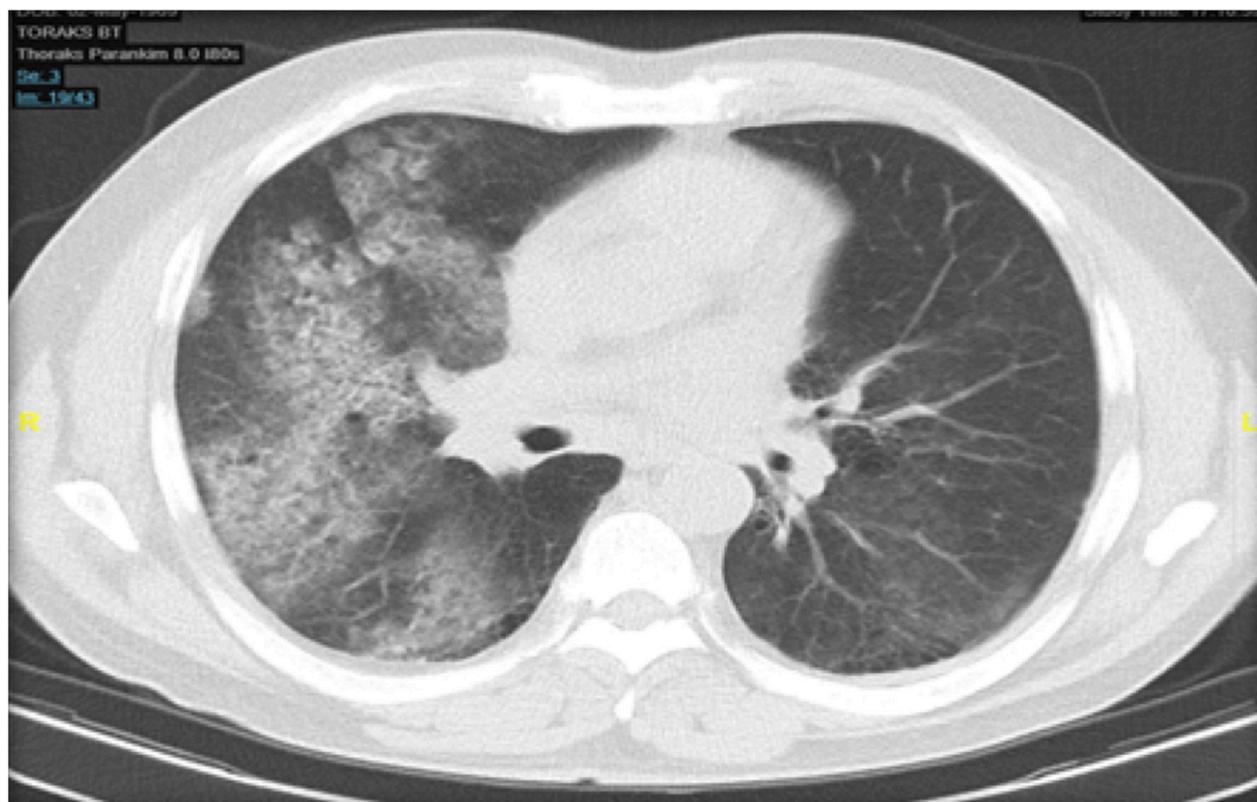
The appearance of the lesions in the chest computed tomography of the case.
